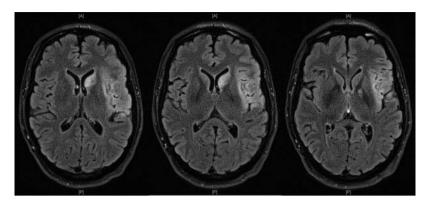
MRI scan 10 days post-stroke confirming the presence of an ischaemic lesion in the left hemisphere, encompassing the caudate nucleus, the insula, the anterior tip of the superior temporal lobe, and the parietal cortex.
